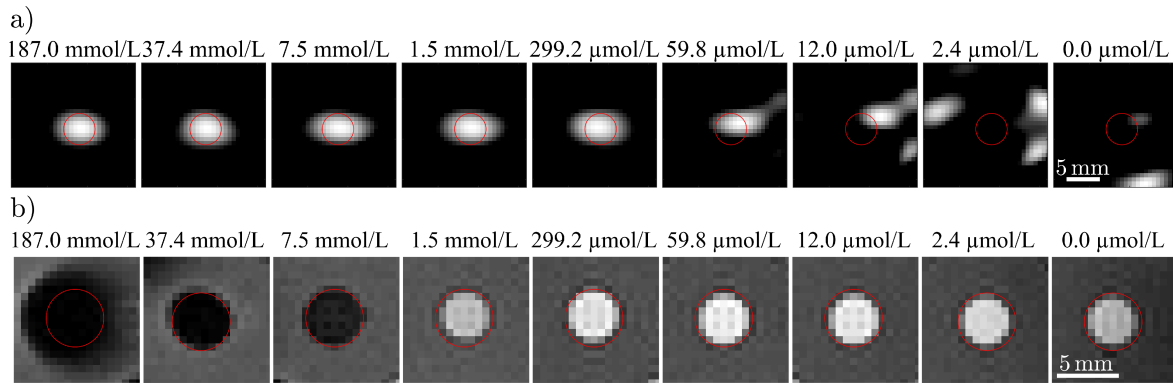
MNP samples diluted in CuSO_4 -solution imaged by MPI (a) and MRI (b). The nominal sample positions are visualized by red circles. The color bars of the MPI images were normalized individually by the maximal intensity of each image for improved visibility. Imaging artifacts hamper a clear localization of the sample positions for concentrations below $59.8 \mu\text{mol/L}$ in MPI and above 37.4 mmol/L in MRI.
